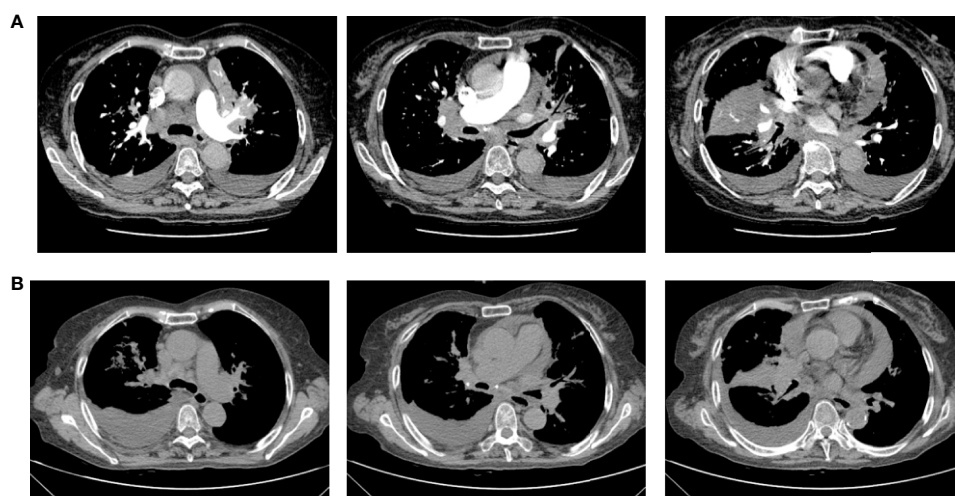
Chest computerized tomography (CT) scan images of patient one before and after one month of osimertinib treatment. (A) The images were before osimertinib treatment. (B) The images of were receiving osimertinib treatment after one month.
